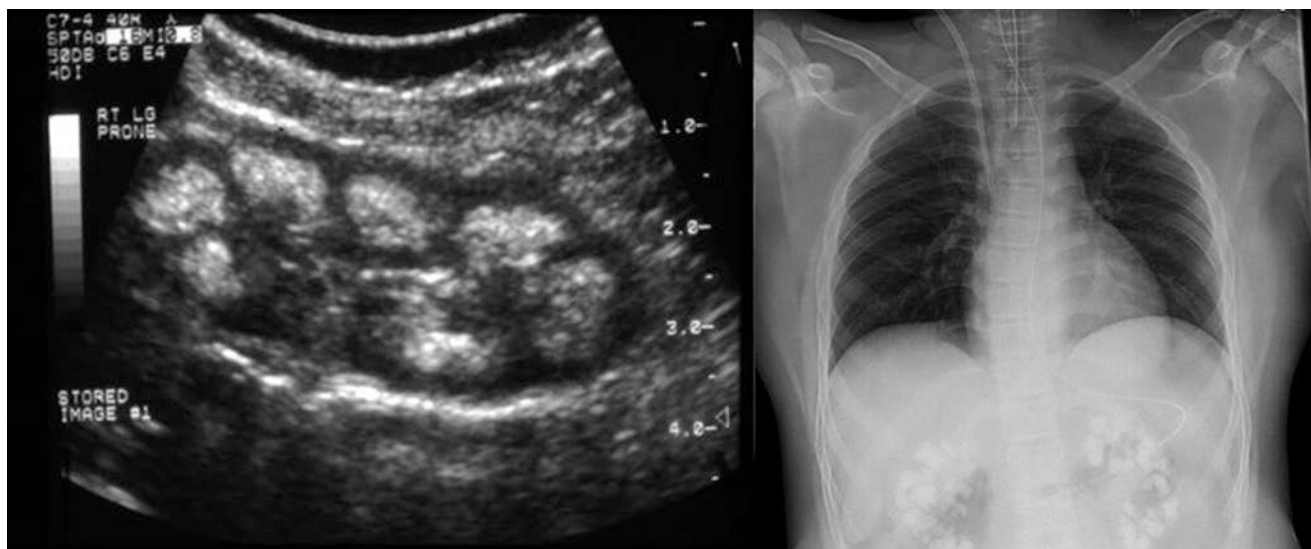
Radiological findings in primary hyperoxaluria: ultrasound coronal section of right kidney shows echogenic medulla and X-ray including the upper abdomen reveals renal calcification of medulla in keeping with nephrocalcinosis
